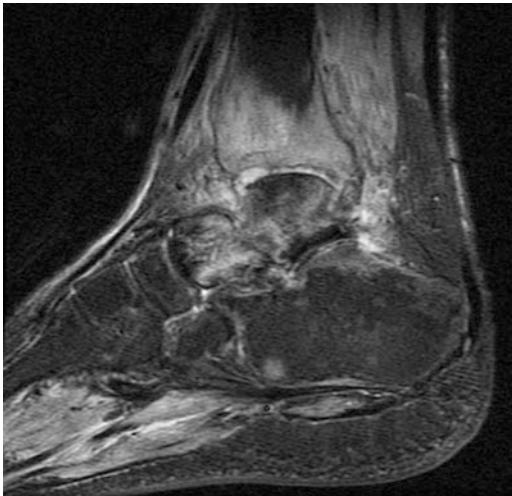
Septic arthritis of the ankle on MRI. Infection occurred after hardware removal following talocalcaneal arthrodesis. Noted osseous changes of the tibia and talus as well as increased signal intensity in the tibiotalar joint
